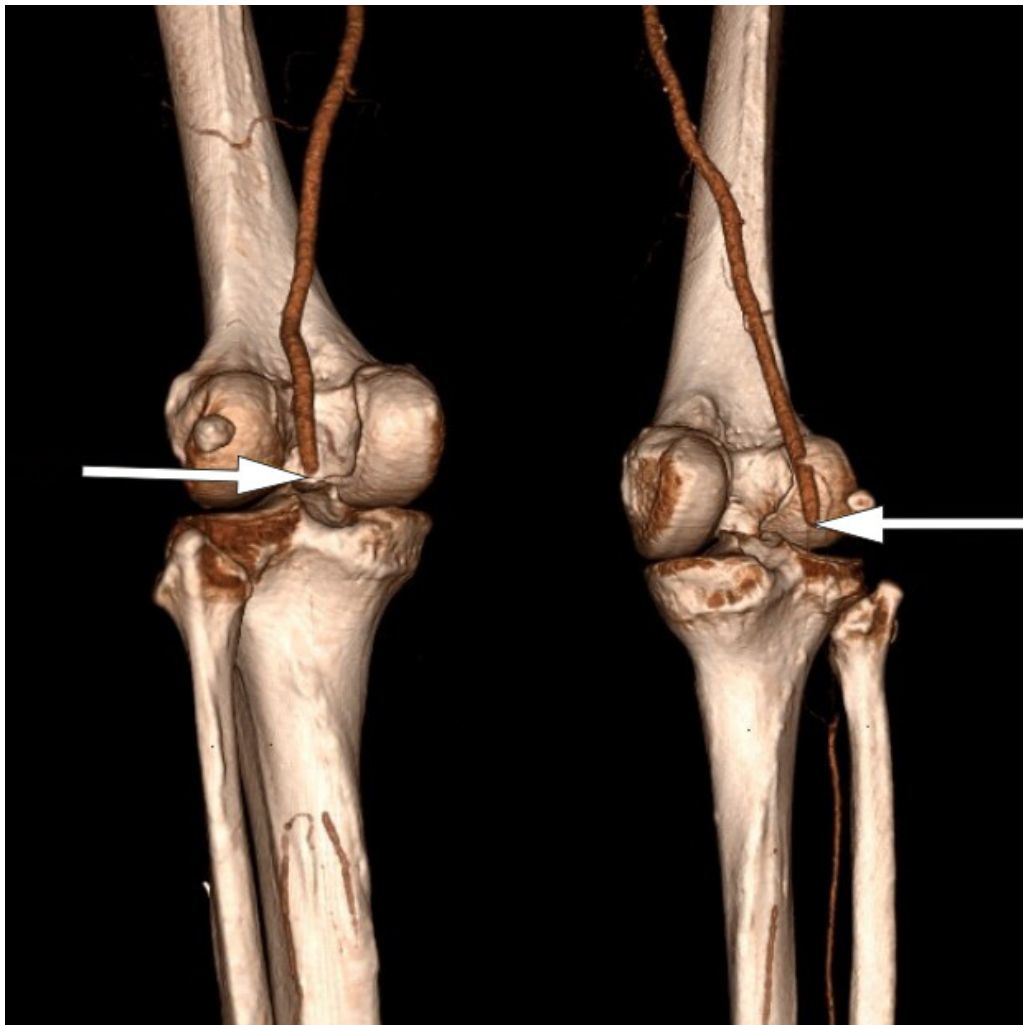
CT angiography shows complete bilateral occlusion of the popliteal arteries.
